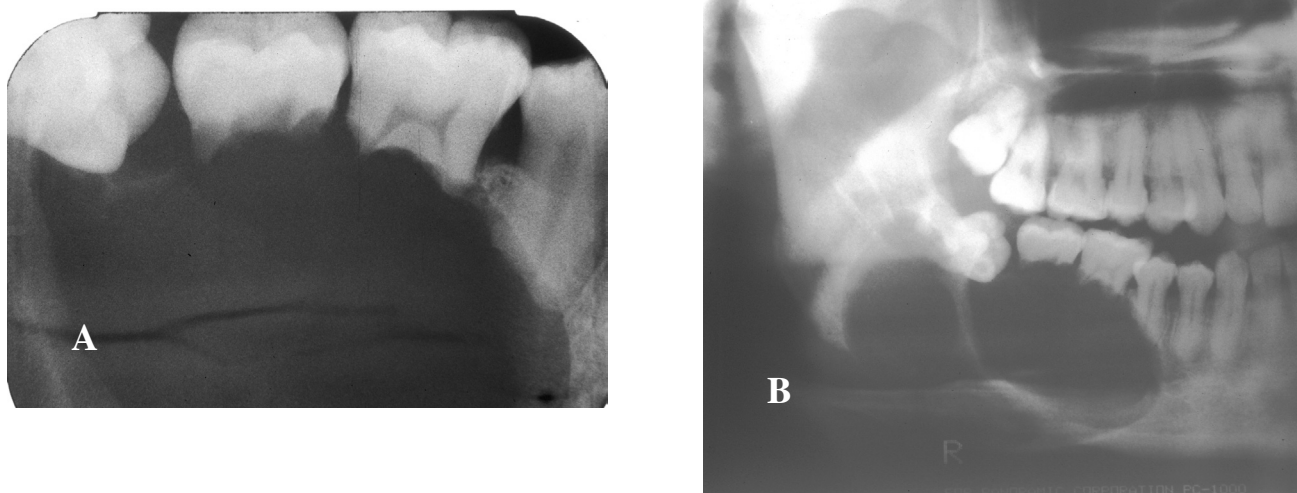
An ameloblastoma present in a 27-year-old male who presented with facial swelling and mobility of right mandibular teeth. A. Periapical radiograph obtained with the presumptive diagnosis of infection. Advanced root resorption was noted due to the presence of an aggressive neoplasm. B. Panoramic radiograph shows a multilocular radiolucency.
